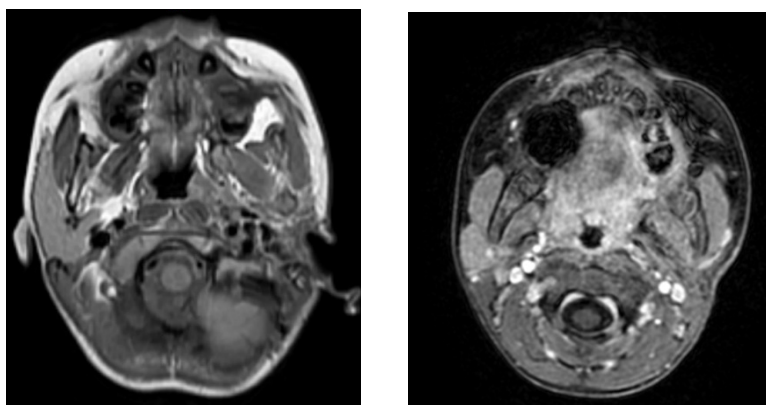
The MRI imaging after 13 cycles of chemotherapy
